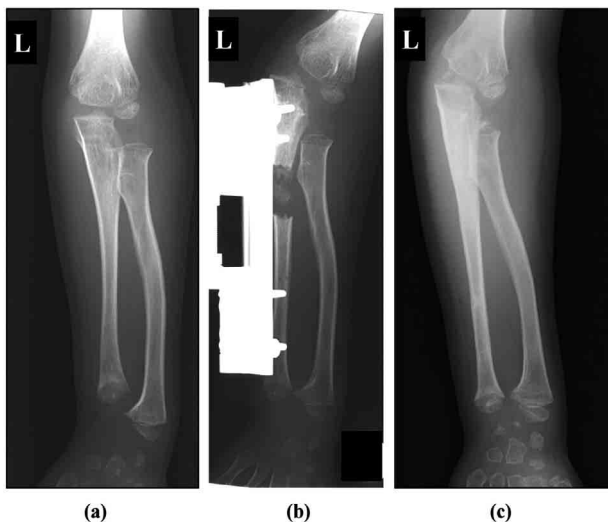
Case 1 : (a) A radiograph of the left forearm of a 9-year-old boy, showing his shortened ulna before osteotomy. (b) A radiograph showing distraction osteogenesis of the left ulna with an Orthofix at the end of the distraction procedure. (c) A radiograph at 544 days after osteotomy, showing appropriate distal joint alignment of the left radius and ulna at 544 days after osteotomy, though the left radial head tended to subluxate.
